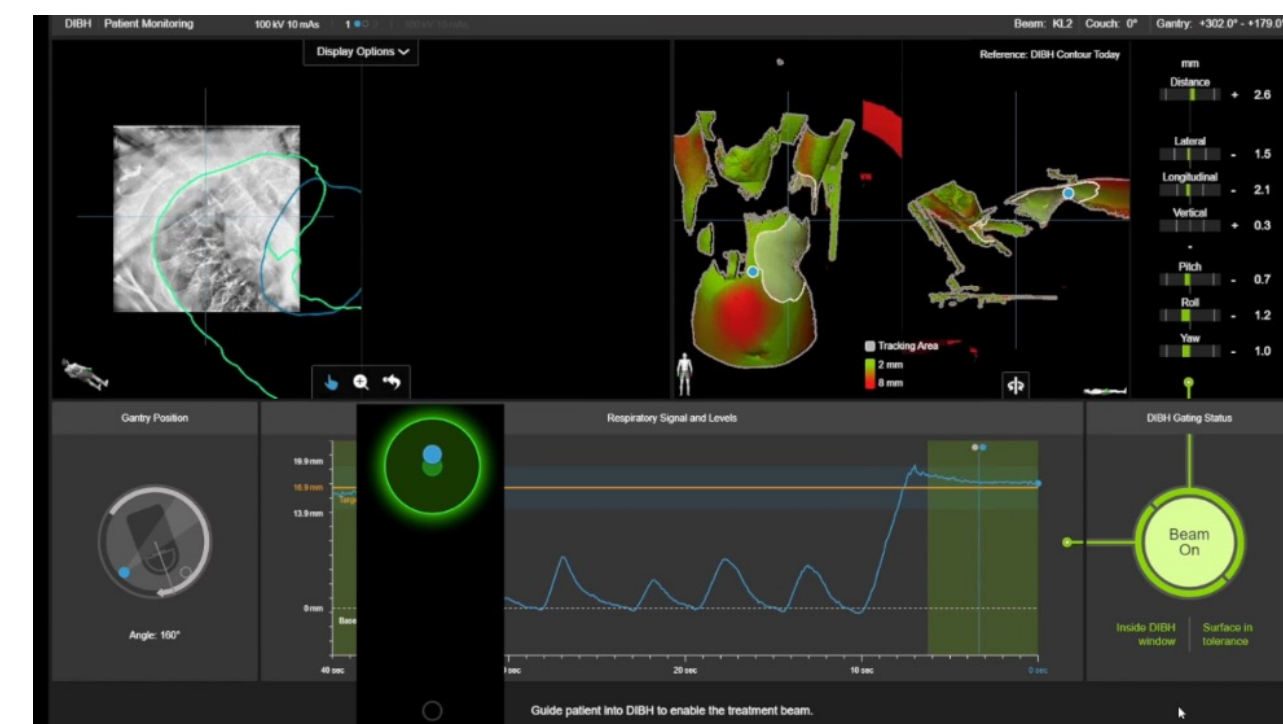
Patient treatment with surface and x-ray monitoring.
